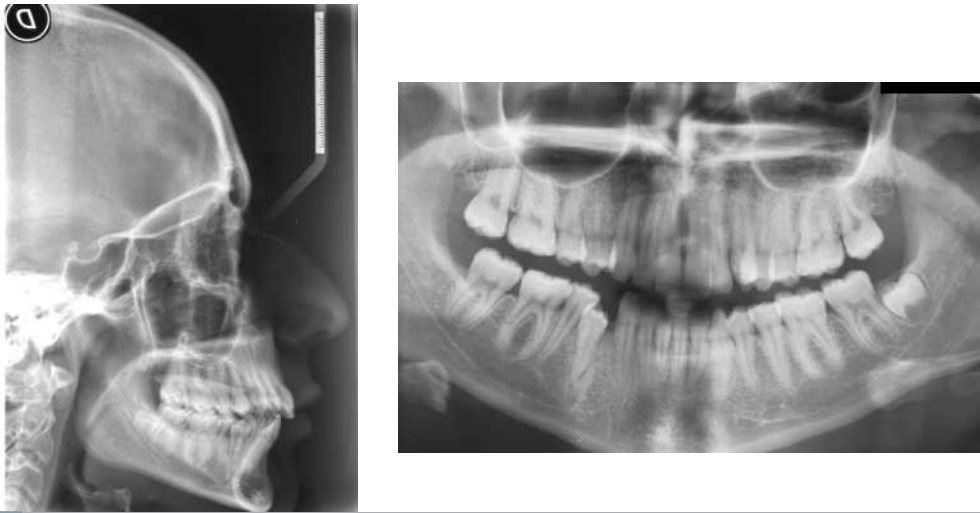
X-ray before treatment
